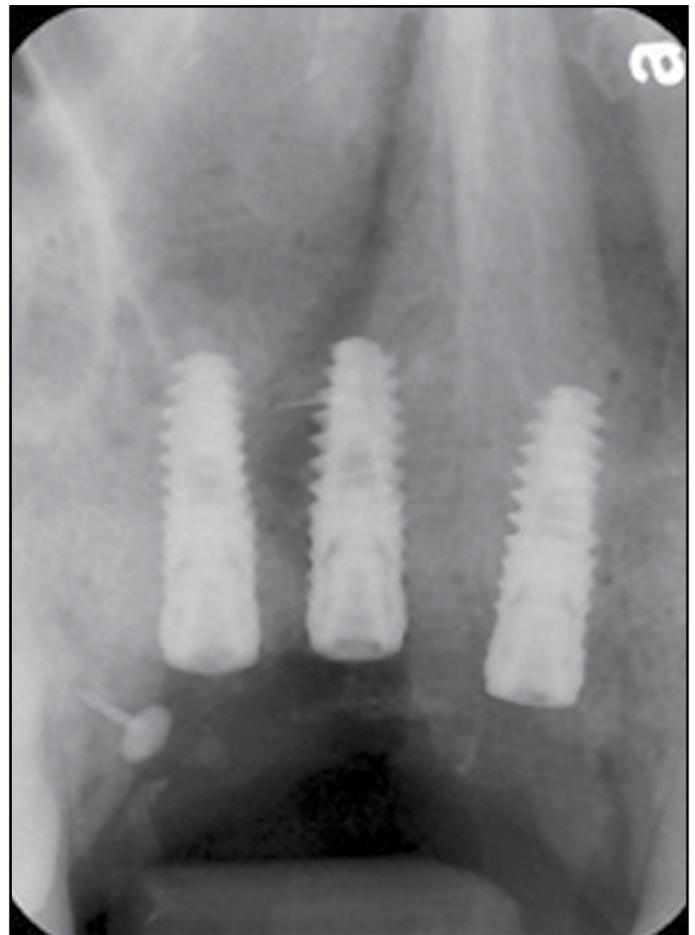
Immediate post-surgical radiograph of 3 implant fixtures delivered in Case 1.
